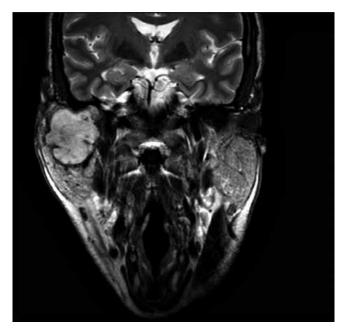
MRI image showing an expansive mass with liquid content inside an irregular and thickened wall. It also shows inhomogeneous and widespread contrast enhancement.
